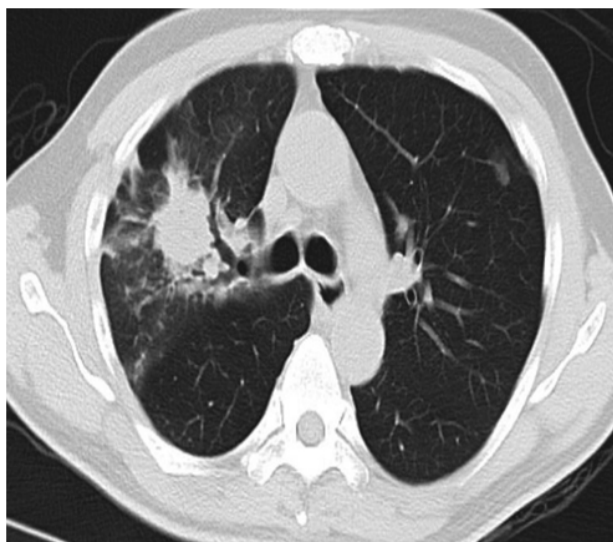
Right upper lobe tumour encircled by an infiltrate as shown on a chest CT
